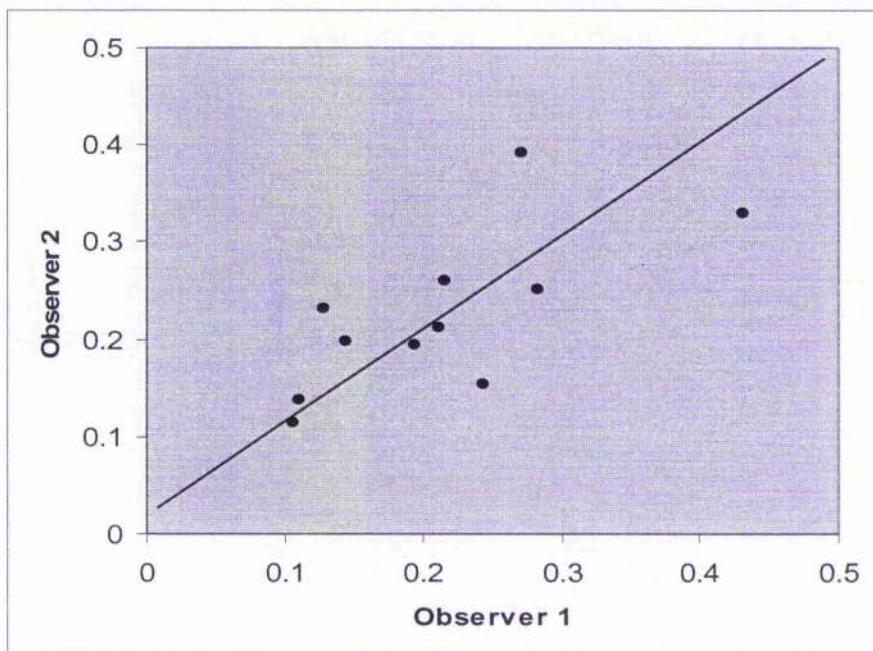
Correlation of Doppler Perfusion Index (DPI) for two observers.
